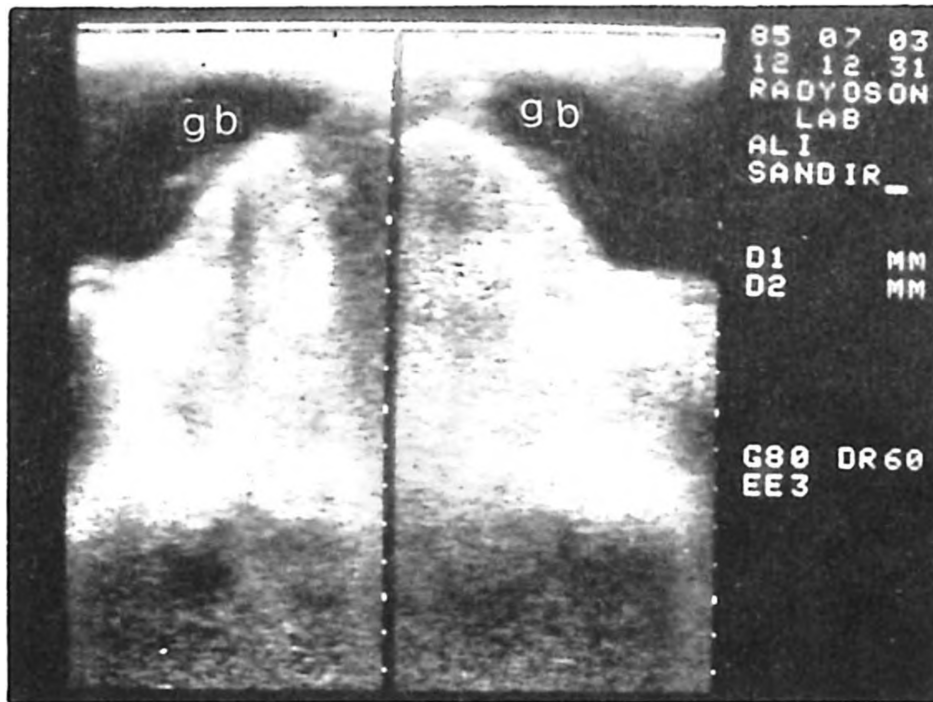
Abdominal ultrasonography showing hydrops of the gallbladder (gb: gallbladder).
